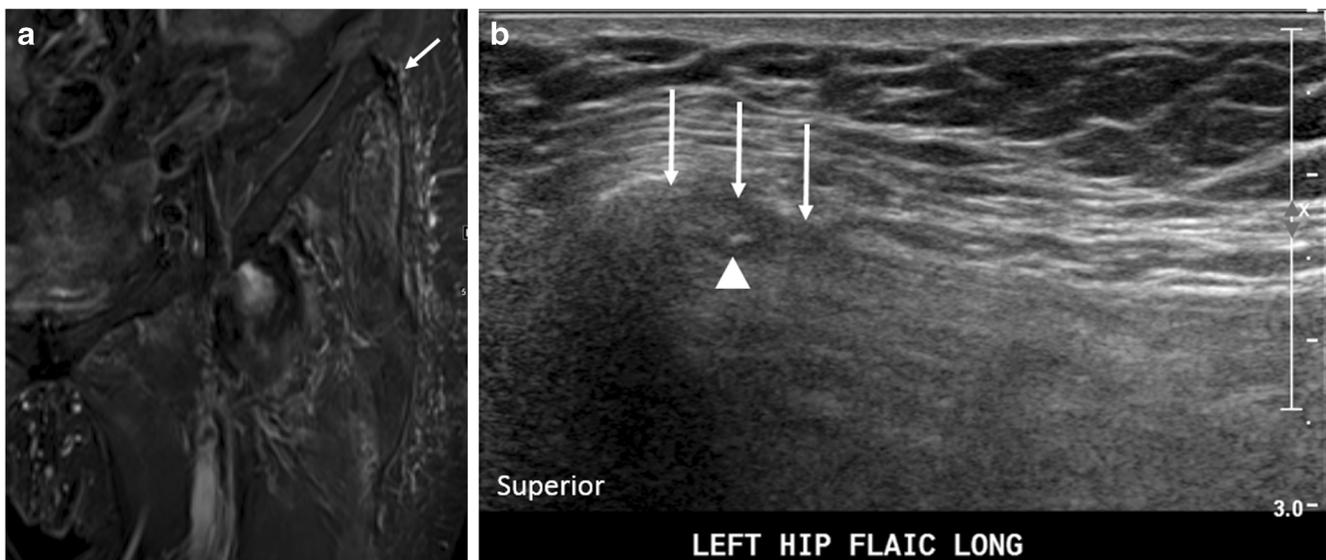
A 90-year-old female with left hip pain who underwent a non-image-guided injection by a clinician at an unspecified location in the region of her left hip. She subsequently presented to her primary care physician with concern for pain at the injection site. The clinician ordered an MRI of the left hip to rule out soft tissue infection at the unspecified injection site. a Thickening, partial-thickness tearing, and mild edema of the left FLAIC was incidentally noted on coronal STIR MRI (*arrow*).
